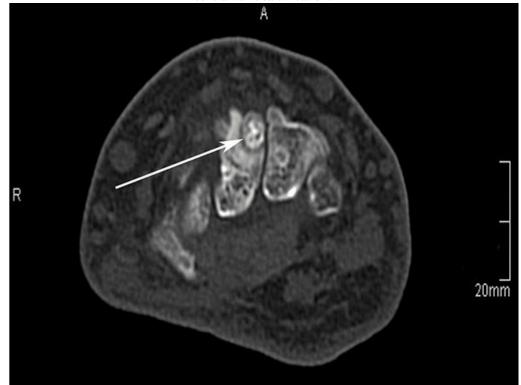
Non - enhanced CT scan of the same patient showing dorsal capitate rounded lucent nidus which has focus of central faint calcification.
